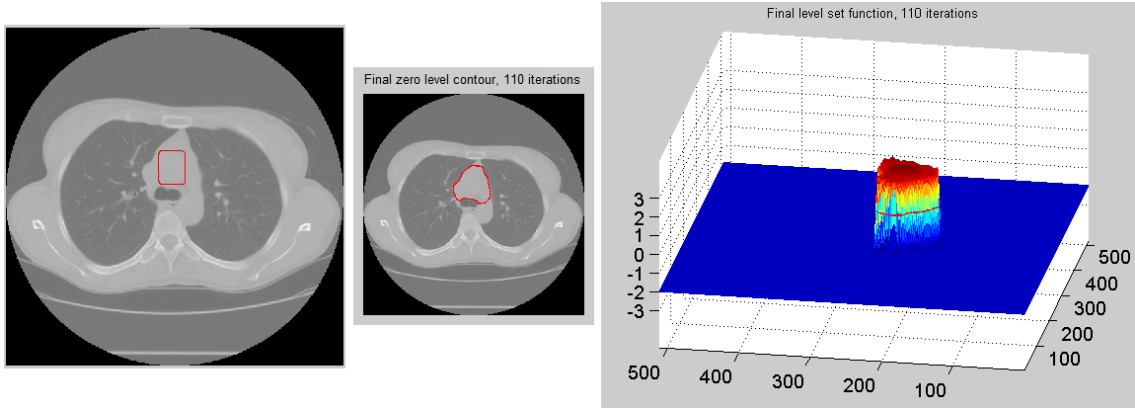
Heart segmentation in a CT image using level set algorithm.
